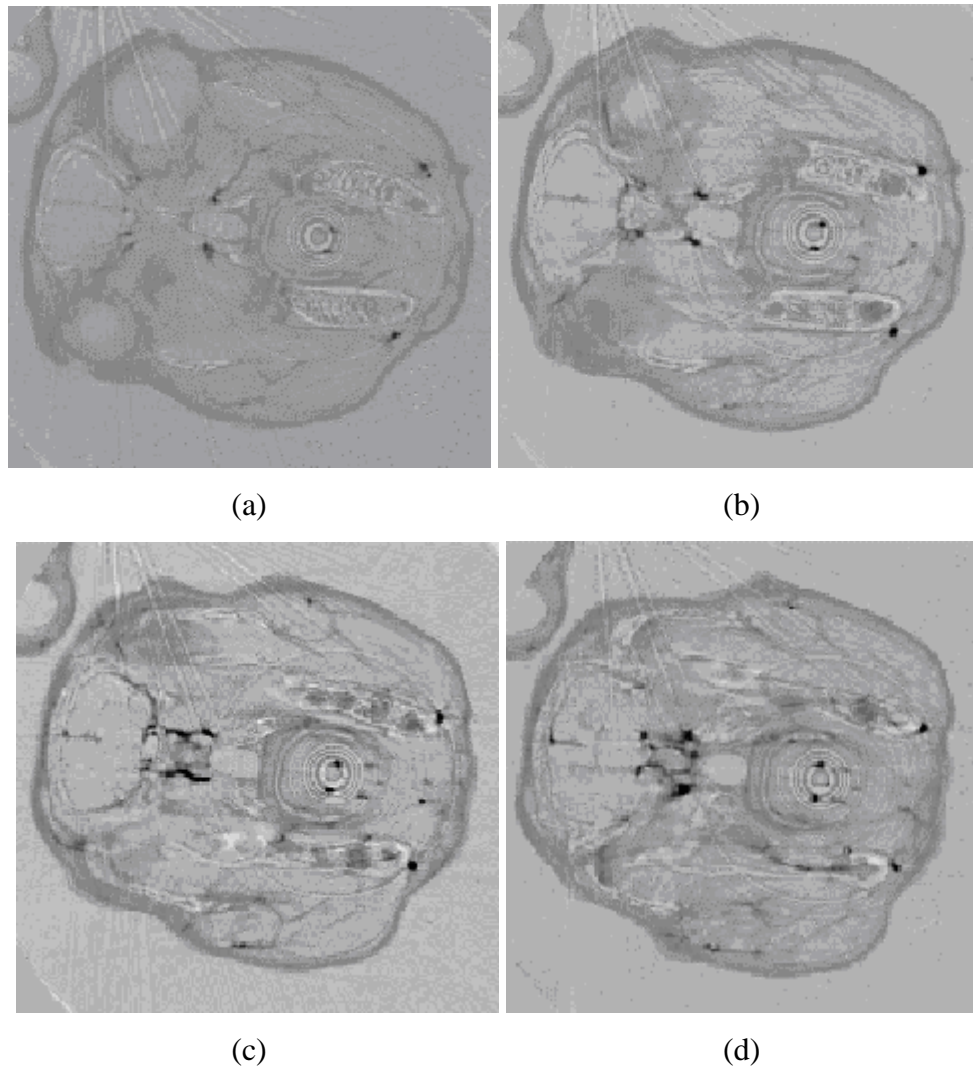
Image series acquired with Ge detector in tomography mode; helical CT scan; pixel size 350 x 350 μm ; Iomeprol[®] 1 mL/sec for 3 seconds (total volume of 3 mL). Images were acquired 3 sec (a), 4 sec (b), 5 sec (c) and 6 sec (d) after injection. (reprinted with permission)
